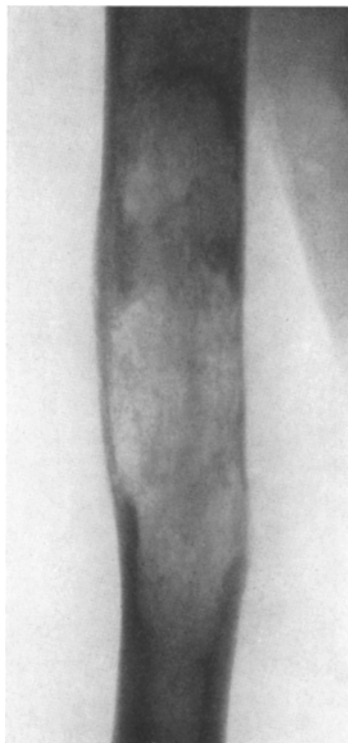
Case 1. Roentgenogram of humerus showing destruction of midshaft cortex with a radiolucent defect extending upward toward head. AFIP Acc. 823205
